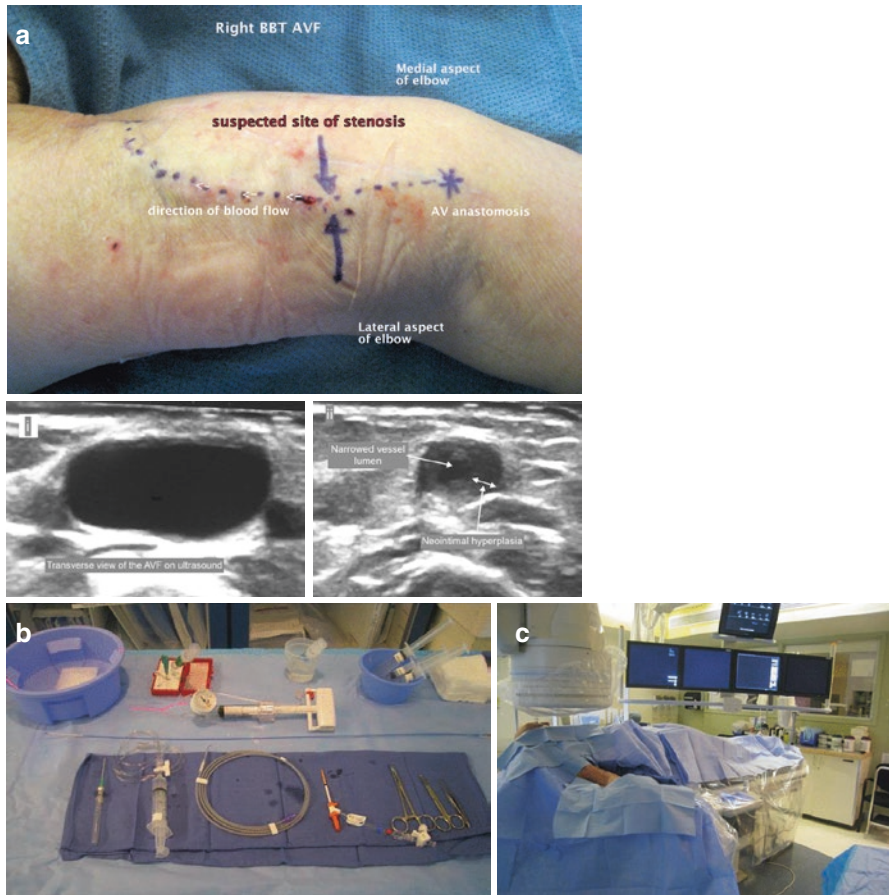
(a) Right arm of the patient. Note the needling sites on the medial side of the arm and the presence of a scar that runs along the AVF. This patient has a right brachio-basilic arteriovenous fistula. Assess the direction of blood flow and the possible site of stenosis. Confirm the site of stenosis using ultrasound. (i) shows the appearance of a non-stenotic segment on transverse view. (ii) shows the appearance of the stenotic segment on ultrasound (b) Prepare your equipment on a table in a sterile fashion. (c) Clean and drape the patient, leaving only the area of interest exposed. Cover the sides of the table and image detector with transparent sterile sheets
